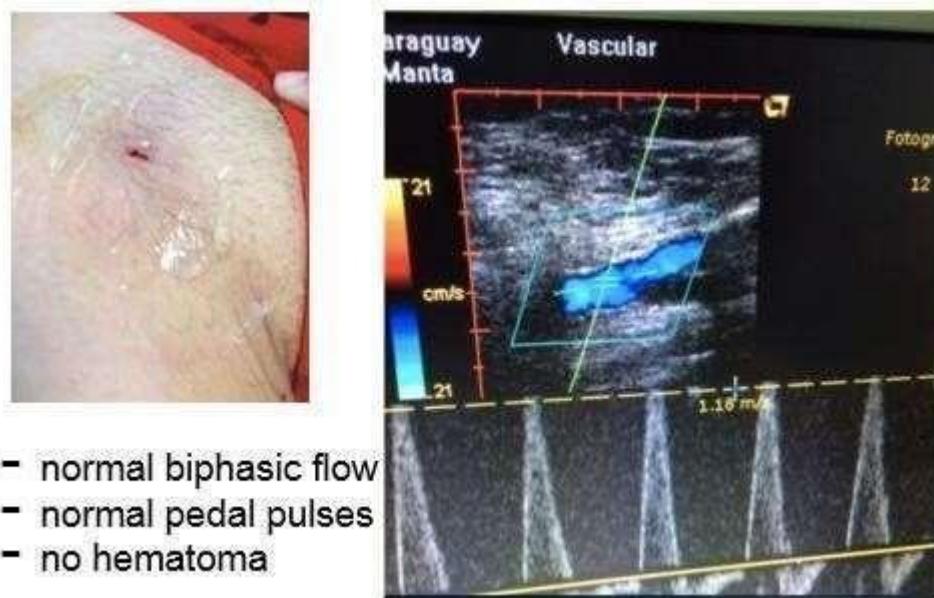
FIH Puncture Site and Duplex Ultrasound Photos
